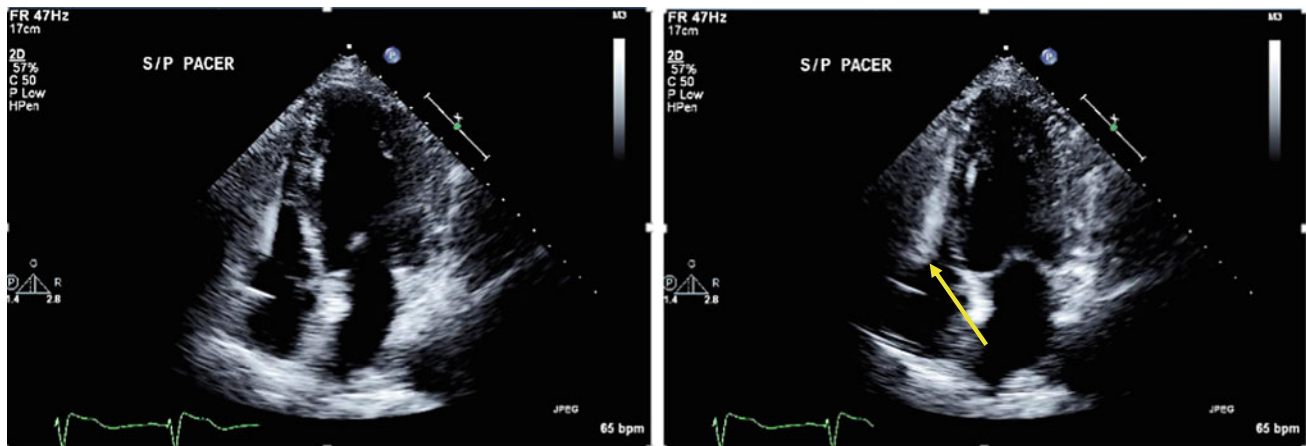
LV Ejection fraction 44% post-CRT-D implantation seen in apical four-chamber view (left: end diastolic frame, right: end systolic frame). Pacemaker wire noticed in right ventricle (arrow)
